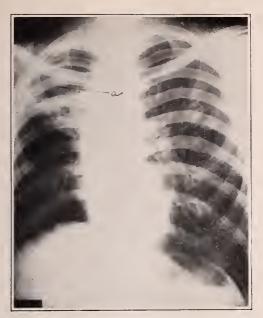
Case XV. Roentgenogram of October, 1931. Very large cavity in upper right lobe, with infiltration density below it (a).
